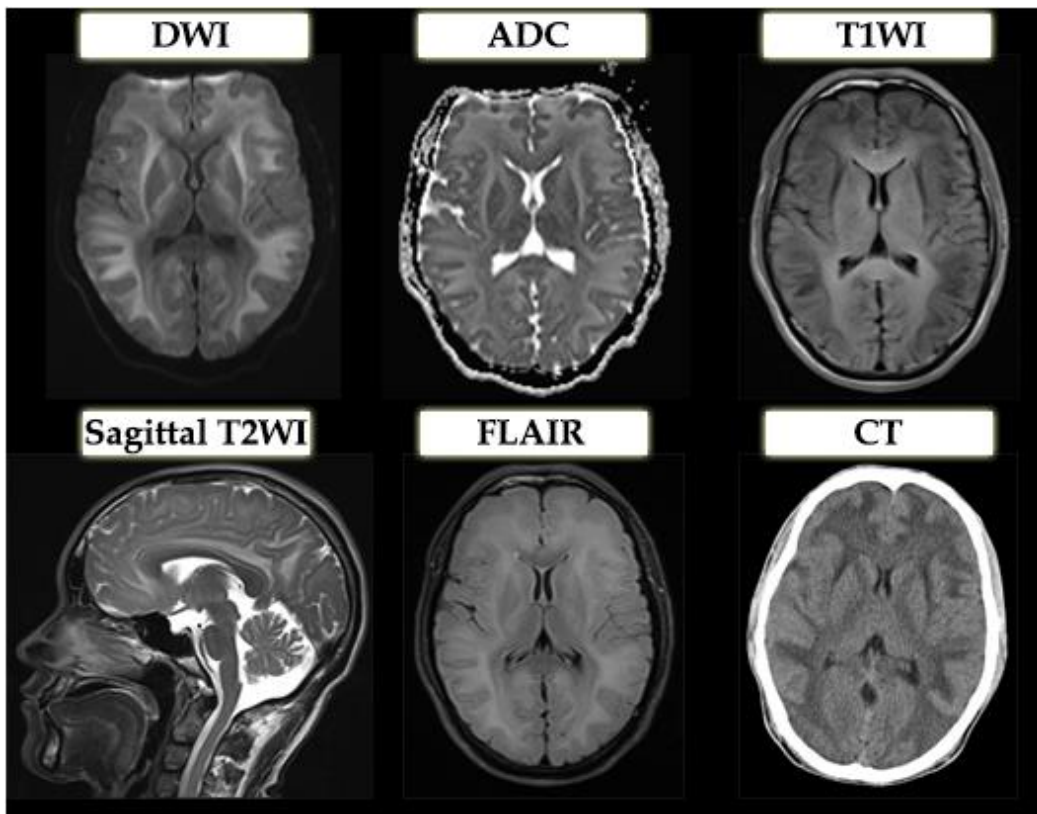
Patient's imaging studies at the time of admission; Computed tomography (CT) shows that the gray-white matter differentiation is preserved, diffuse white matter hypodensity on both cerebral hemispheres. MRI demonstrates bilateral symmetrical abnormal signals in subcortical U-fibers, corticospinal tract (including internal and external capsules), corpus callosum, periventricular white matter and cerebellar dentate nucleus. MRI revealed no abnormal signals in cerebral grey matter, corona radiate, brain stem, and cerebellar hemispheres.
